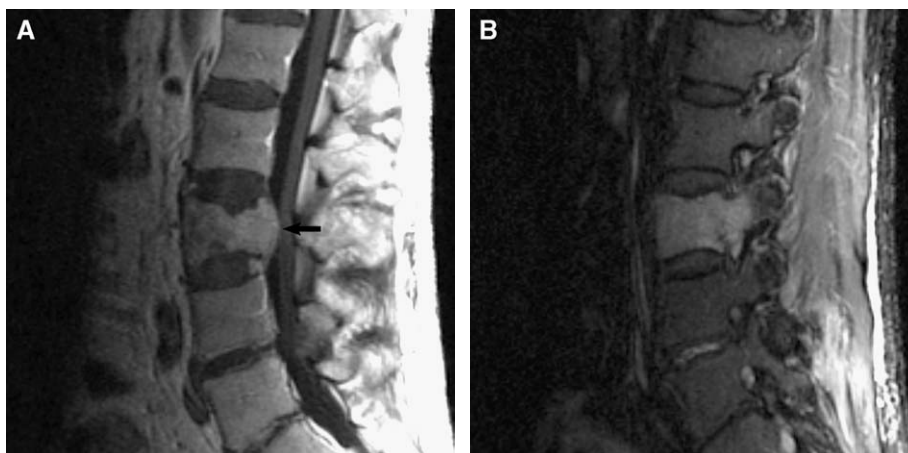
Sagittal T1-weighted image after intravenous contrast administration without (A) and with (B) fat saturation demonstrates the utility of fat saturation in a patient with metastatic colon cancer. (A) There is rounded displacement of the L3 posterior cortical line (*arrow*) on the image without fat saturation that belies the malignant nature of the lesion, but the tumor signal intensity is indistinguishable from adjacent fatty marrow, a common pitfall. (B) Fat saturation darkens the fatty marrow, making the metastatic lesion conspicuous.
